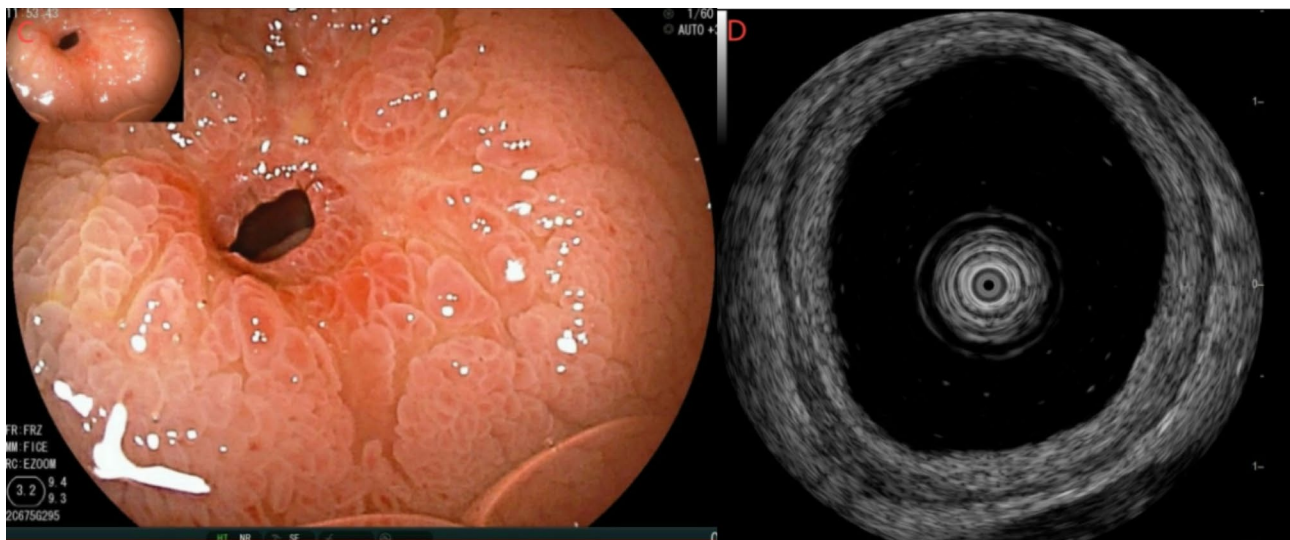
C: Endoscopic findings showing concentric stenosis, with thin white coated ulcers around the stenosis, indicating moderate disease activity. D: Small intestinal endoscopic ultrasound showing clear differentiation of the layers of the intestinal wall and moderate thickening of the intestinal wall
